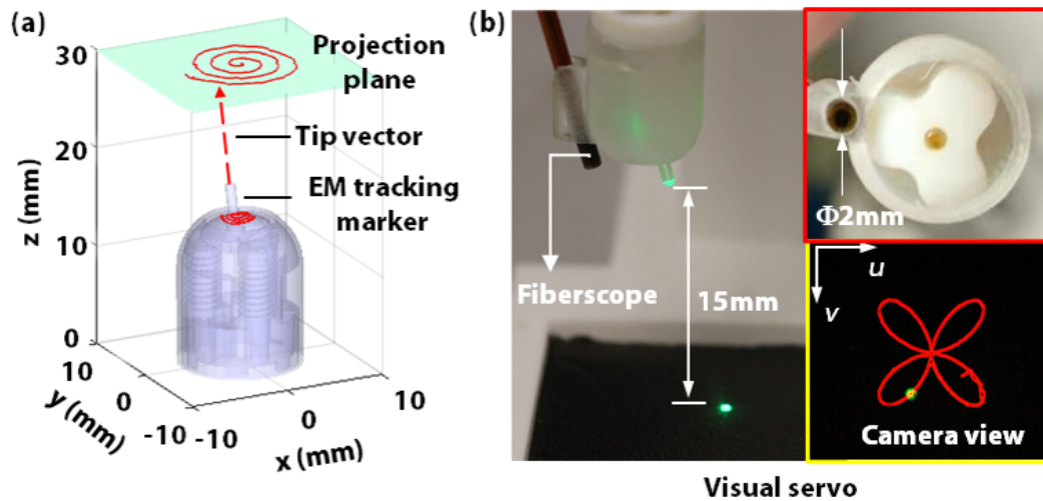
Lab-based laser beam steering control. (a) Path following of the laser spot on a projection plane using the soft laser manipulator. The laser spot position can be determined based on the robot tip position and orientation measured with an EM tracking system. (b) Laser spot visual servoing is achieved with an MRI-compatible fiberscope.
